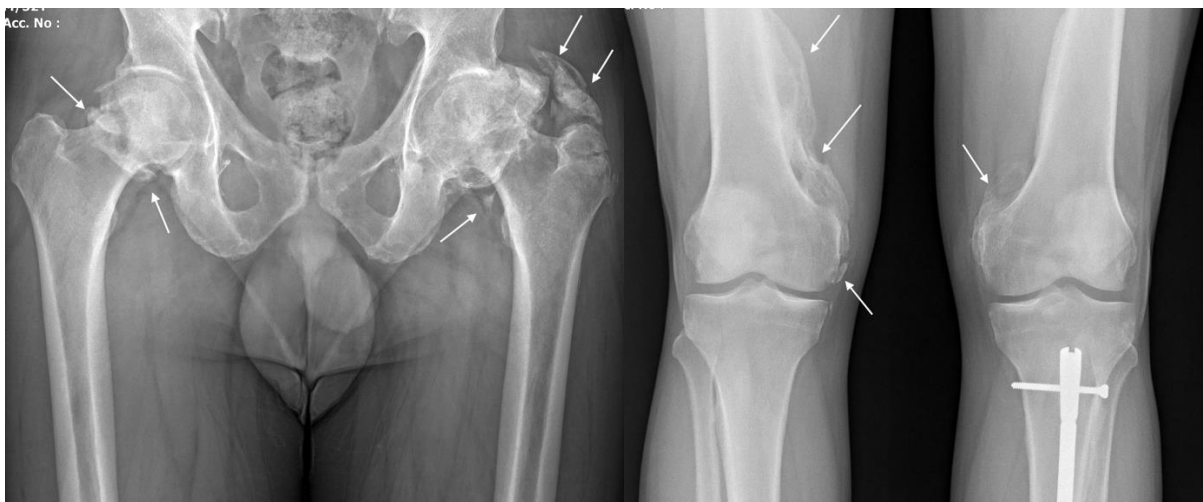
X-ray of the hips (left) and knees (right) from anteroposterior projection obtained on 25. 05. 2023, i.e. approximately 2.5 years post admission. Heterotopic ossifications (HOs) are seen bilaterally in both hip (left) and knee (right) joints as depicted by the arrows. No progression was noted from the previous X-rays. On the left knee, an intramedullary nail can be seen following osteosynthesis performed in the year 2012 due to a tibial fracture.
